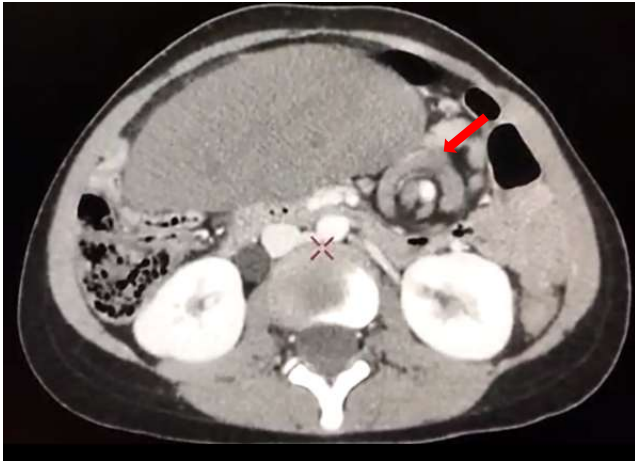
CT image showing a wandering spleen located in the lower quadrant of the abdomen, the red arrow indicates a whorled appearance of the splenic pedicle.
